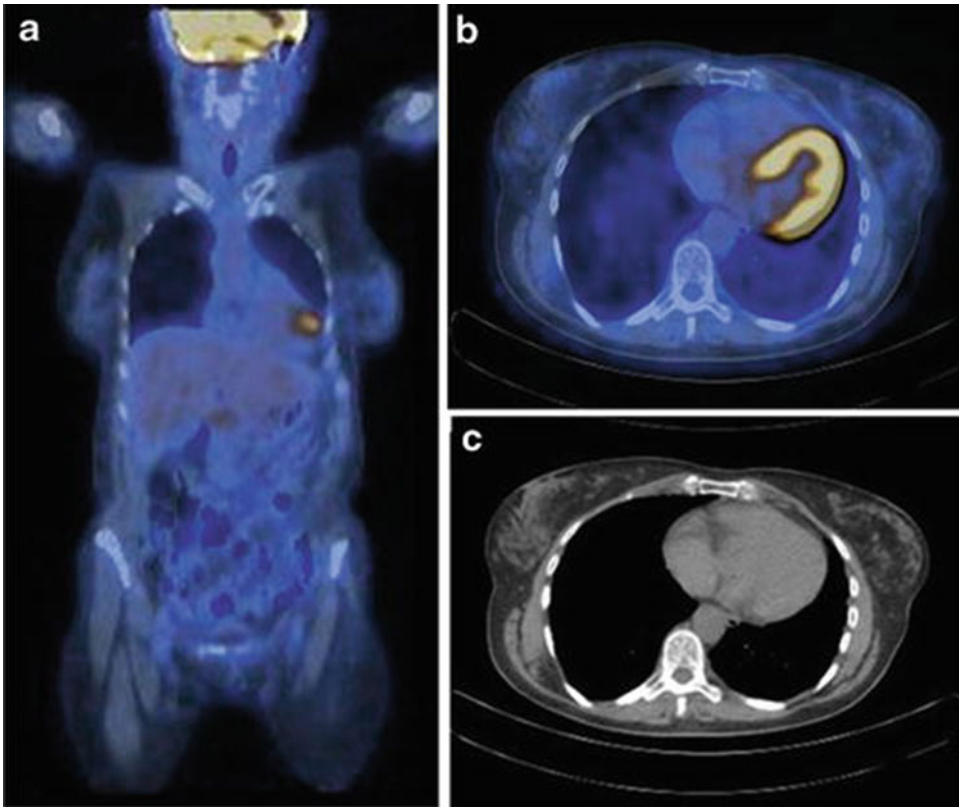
Fused coronal [^{18}F]FDG PET/CT (a) and axial images ((b) fused PET/CT and (c) low-dose CT) failed to detect the malignant left breast lesion
